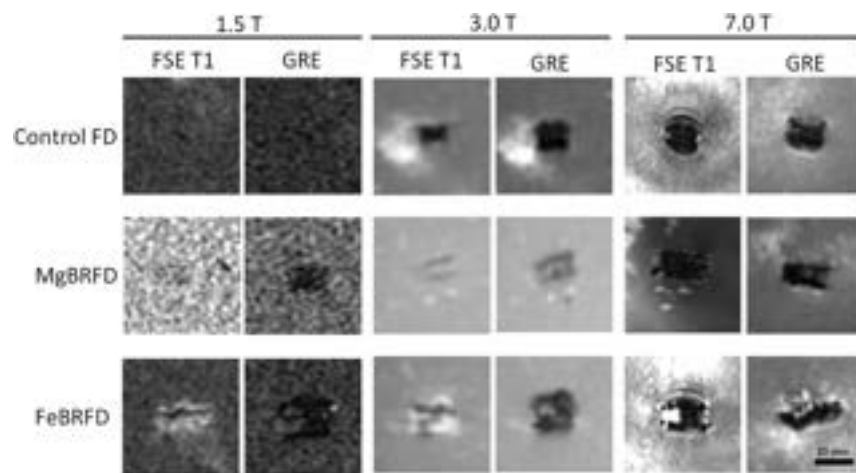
MR imaging artifacts induced by the control FD, MgBRFD, and FeBRFD using a fast spin-echo sequence with T1 weighting (FSE T1) and a gradient recalled-echo (GRE) scan sequence with 1.5T, 3T, and 7T field strength clinical MR imaging scanners.
